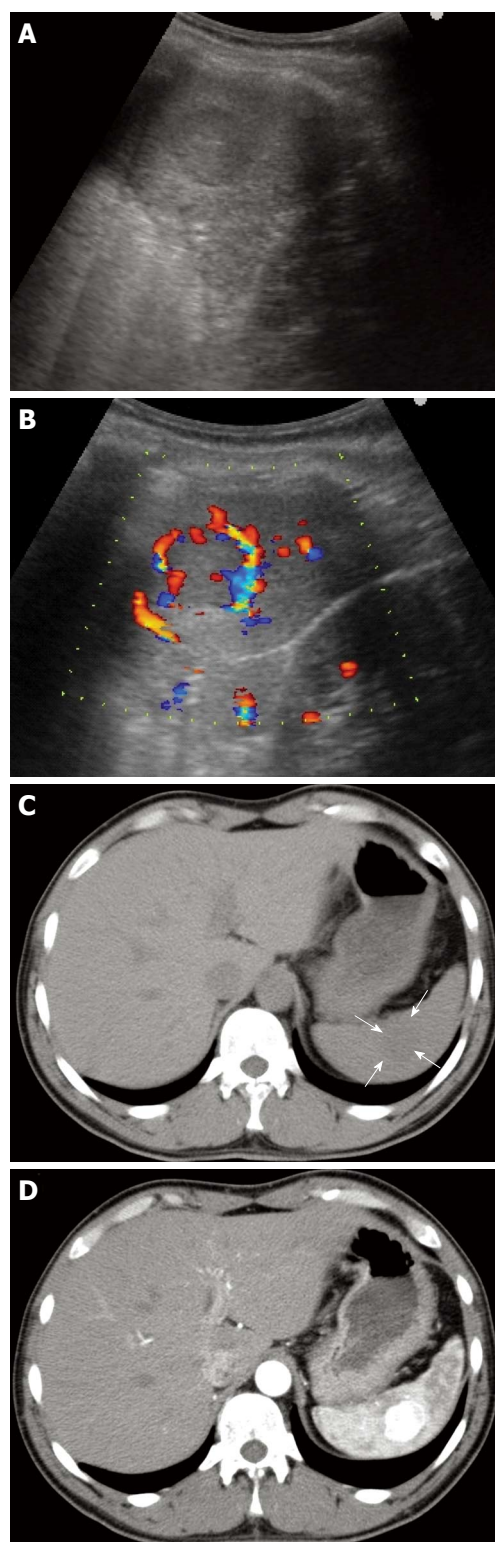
Ultrasonography and computed tomography (CT) of the splenic lesion. A: Gray-scale ultrasonography shows a homogenous and hypoechoic mass at the mid-portion of the spleen; B: Color Doppler sonography shows multiple color circular flow signals within the mass; C: CT shows a slightly lower-density mass in the spleen (arrows); D: The mass demonstrated strong enhancement after the intravenous administration of contrast material.
